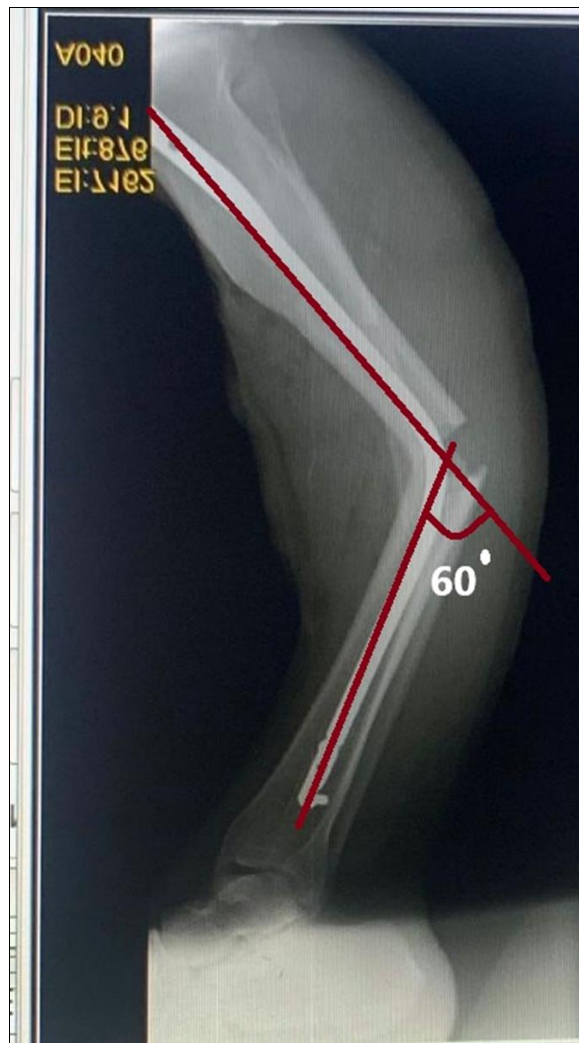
X-ray showing bent tibial IM nail with distal femur fracture.
